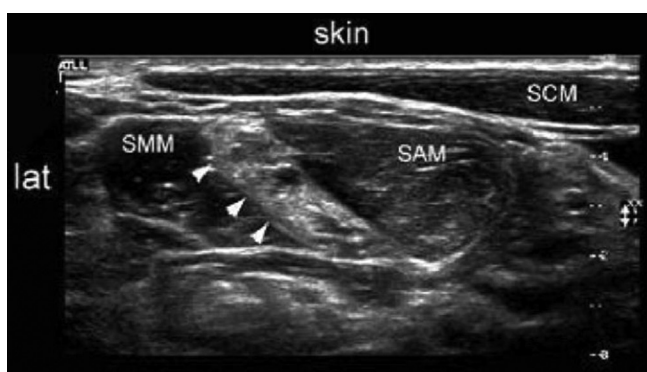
Transverse sonogram showing local anaesthetic spread and distension in the interscalene groove; SCM - sternocleidomastoid, SMM - scalenus Medius muscle, SAM - scalenus anterior muscle
